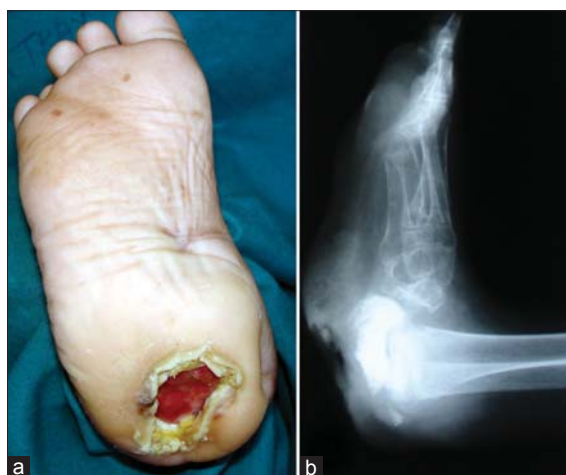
(a) Neuropathic bone deep ulcer, (b) radiograph showing bone destruction
